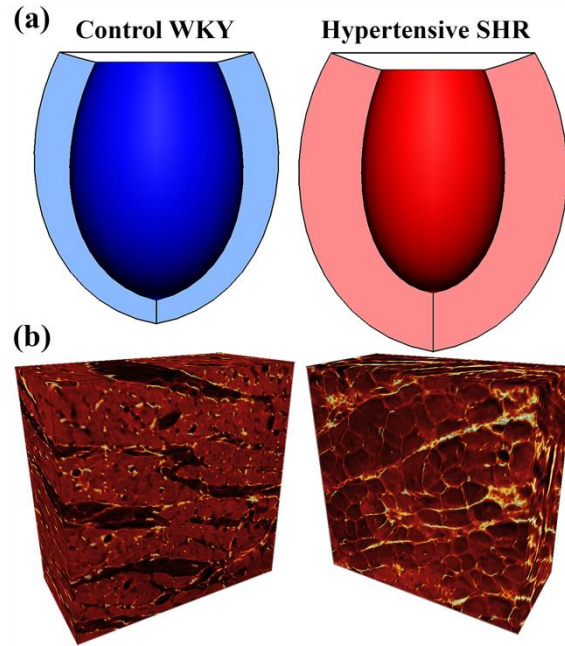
(a) 3D LV FE models constructed from subject-specific *in vivo* MRI data at diastasis. (b) Confocal image volumes: myocytes have variable intensity, while collagen appears bright.
